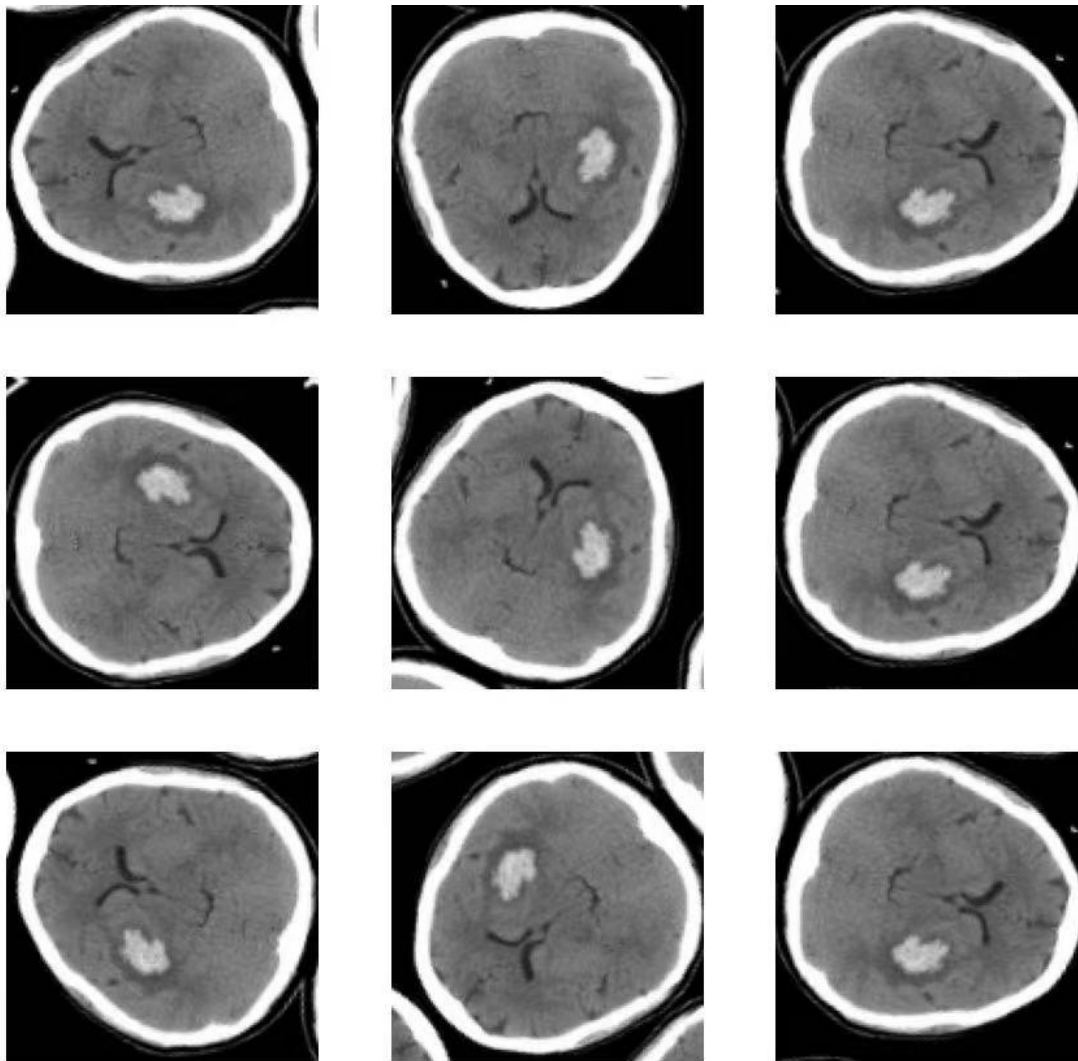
Image of Head CT After Image Augmentation
